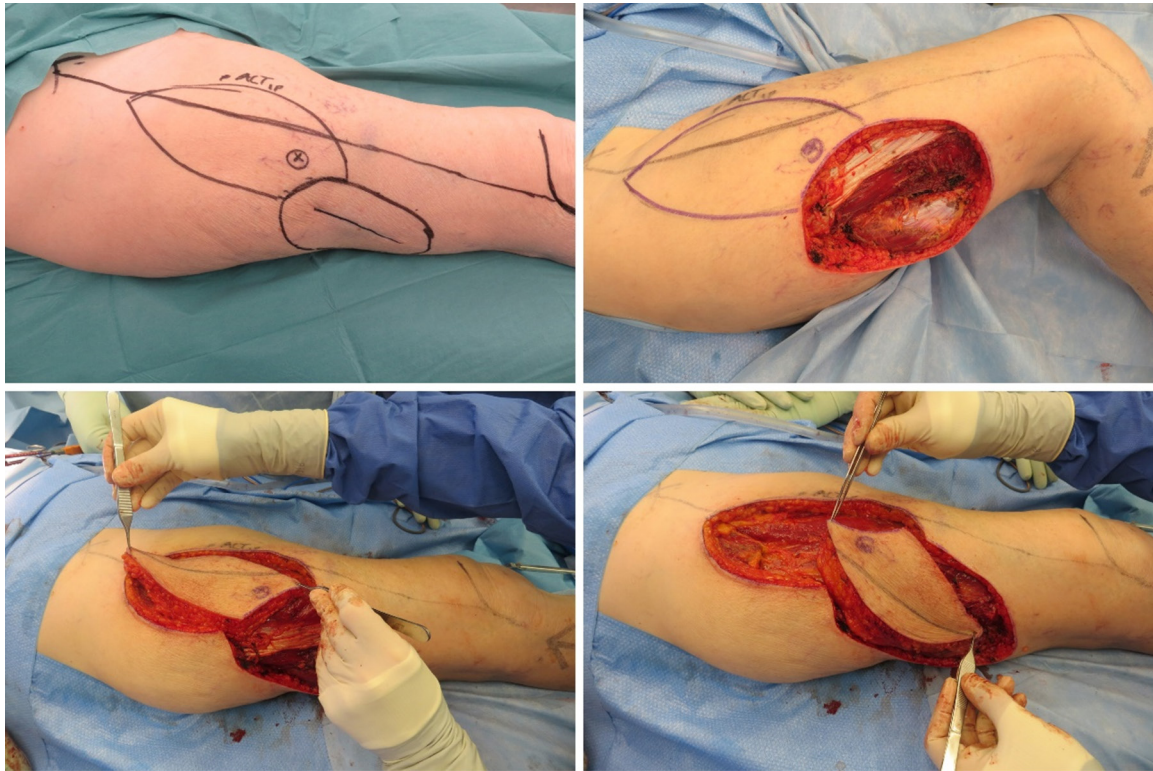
Upper left: preoperative markings of the sarcoma and the anterior lateral thigh flap design. The perforator was mapped using a handheld Doppler device. Upper right: large soft tissue defect on the lateral thigh with exposure of T. rectus iliotibialis, M. vastus lateralis, and M. biceps femoris. Lower left: The anterior lateral thigh flap, measuring 16 cm × 8 cm, was raised. Lower right: the flap was propelled into the defect 130° counter clockwise, comfortably covering the defect
